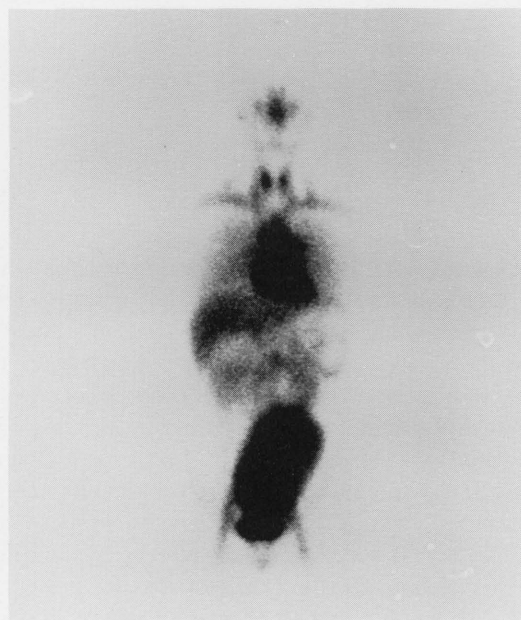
Blood-pool scintigraphy in the anterior view shows a giant hypervascular mass in the pelvis, but no vascular component in the left upper quadrant. Blood volume of the spleen was found to be 690 ml.
